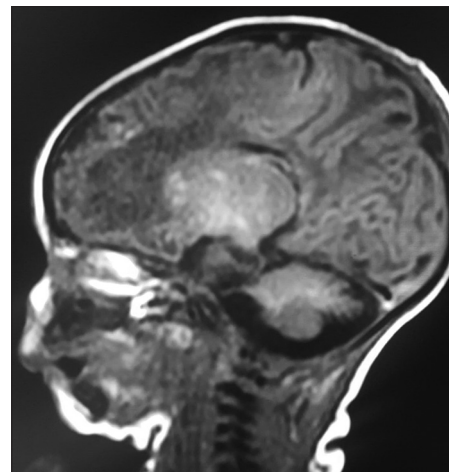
MRI ,corpus callosum agenesis.
